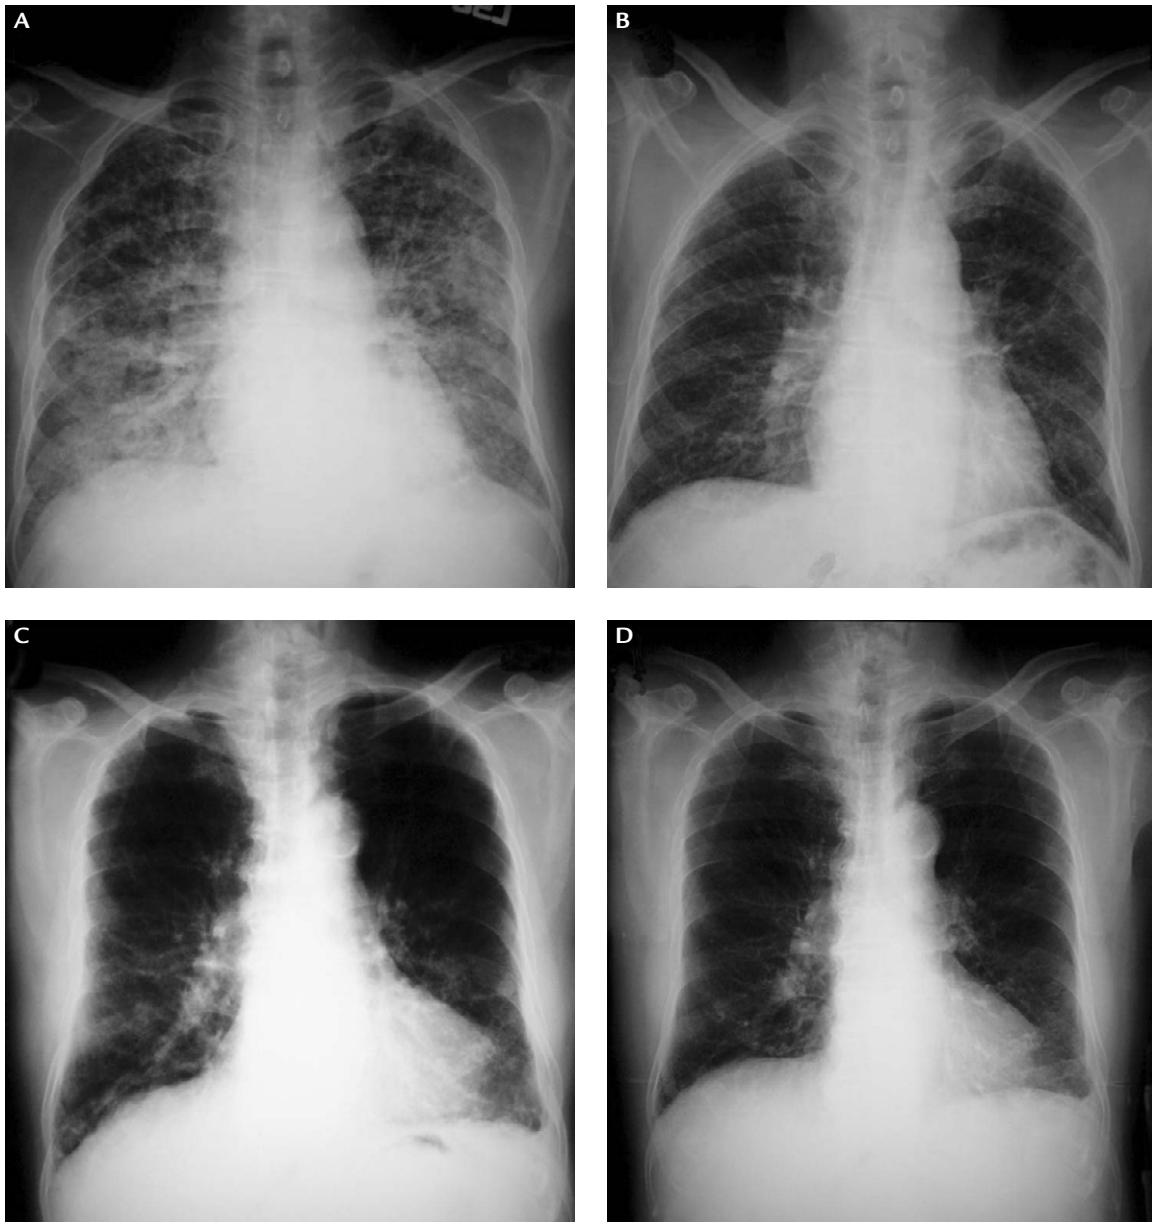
(A) Chest radiograph of patient 1 obtained on admission shows hyperinflation with chronic infiltration over bilateral lungs and increasing bilateral lung marking. (B) Chest radiograph of patient 1 obtained 10 days after admission shows improving infiltration in bilateral lower lung fields. (C) Chest radiograph of patient 3 obtained on admission shows diffuse and irregular increased lung markings in both lower lungs. (D) Chest radiograph of patient 3 obtained 9 months after admission shows linear interstitial infiltrations of left lower lung field improving.
